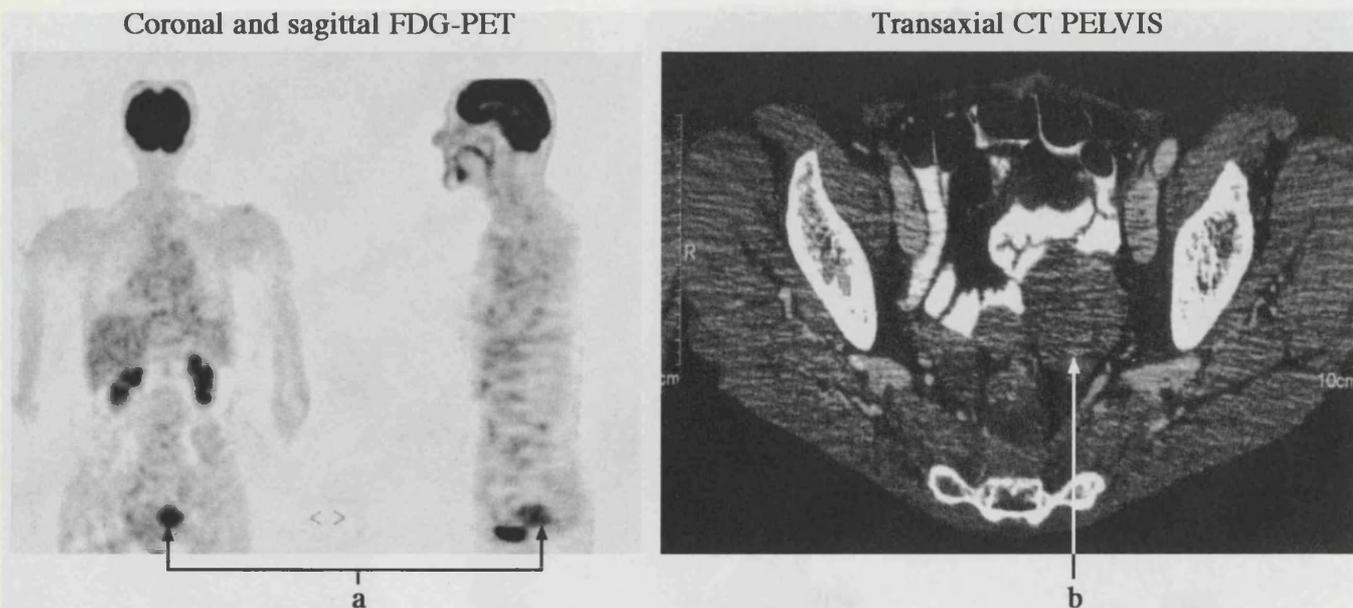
Coronal and sagittal FDG-PET in a patient who previously underwent anterior resection for adenocarcinoma. CEA began to rise, but all imaging and colonoscopy was reported as normal. FDG uptake was demonstrated above and to the left of the urinary bladder (a). A CT scan reported in the light of the FDG-PET scan did demonstrate a lesion (b), but the nature of this was uncertain. At laparotomy the patient was found to have an isolated recurrence of a rectal adenocarcinoma (reproduced with permission of Lancet Oncology).<sup>91</sup>
